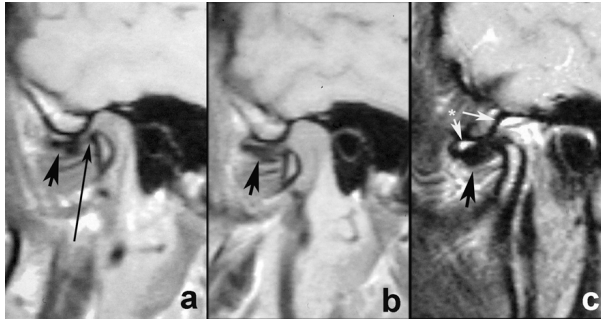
Magnetic resonance images of the right temporomandibular joint in the position of maximum habitual intercuspitation (a), forced anterior position (b) and open mouth position (c). Note: non-reduced anterior displaced disc (short arrow), joint effusion (marked with *), and degenerative changes of cortical condylar head (long arrow).
